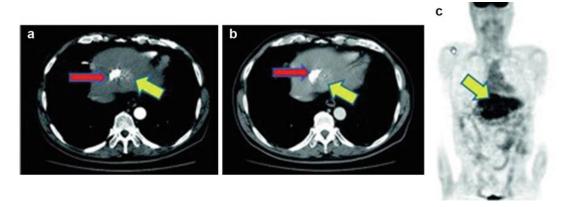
A hepatoma recurrence after arterial chemoembolization. Contrast-enhanced CT at both arterial and portal phase shows a slight enhancement as suspected viable recurrent hepatoma, and a high [¹⁸F]FDG accumulation is
